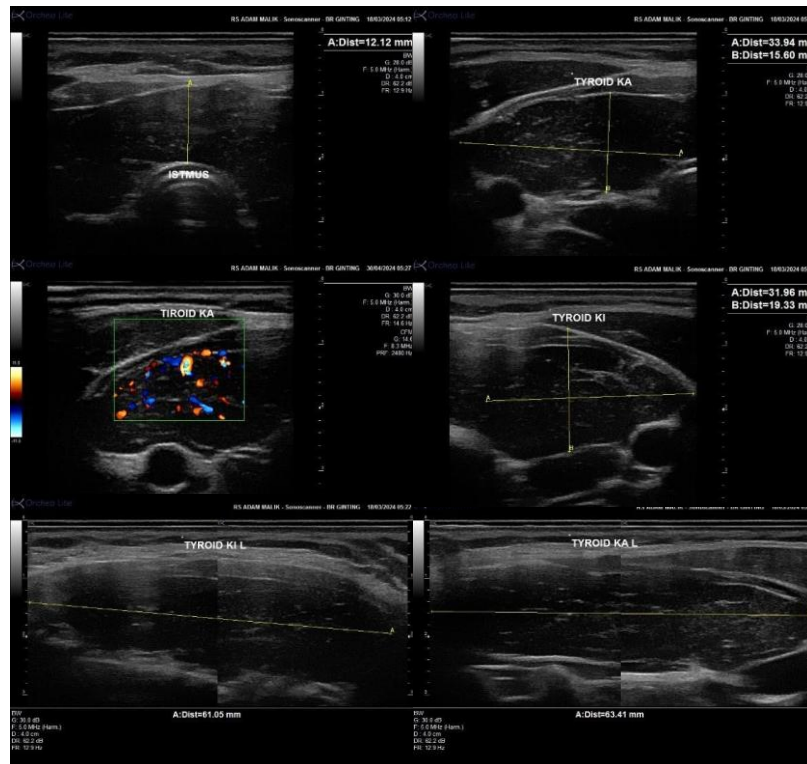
Thyroid ultrasonography
